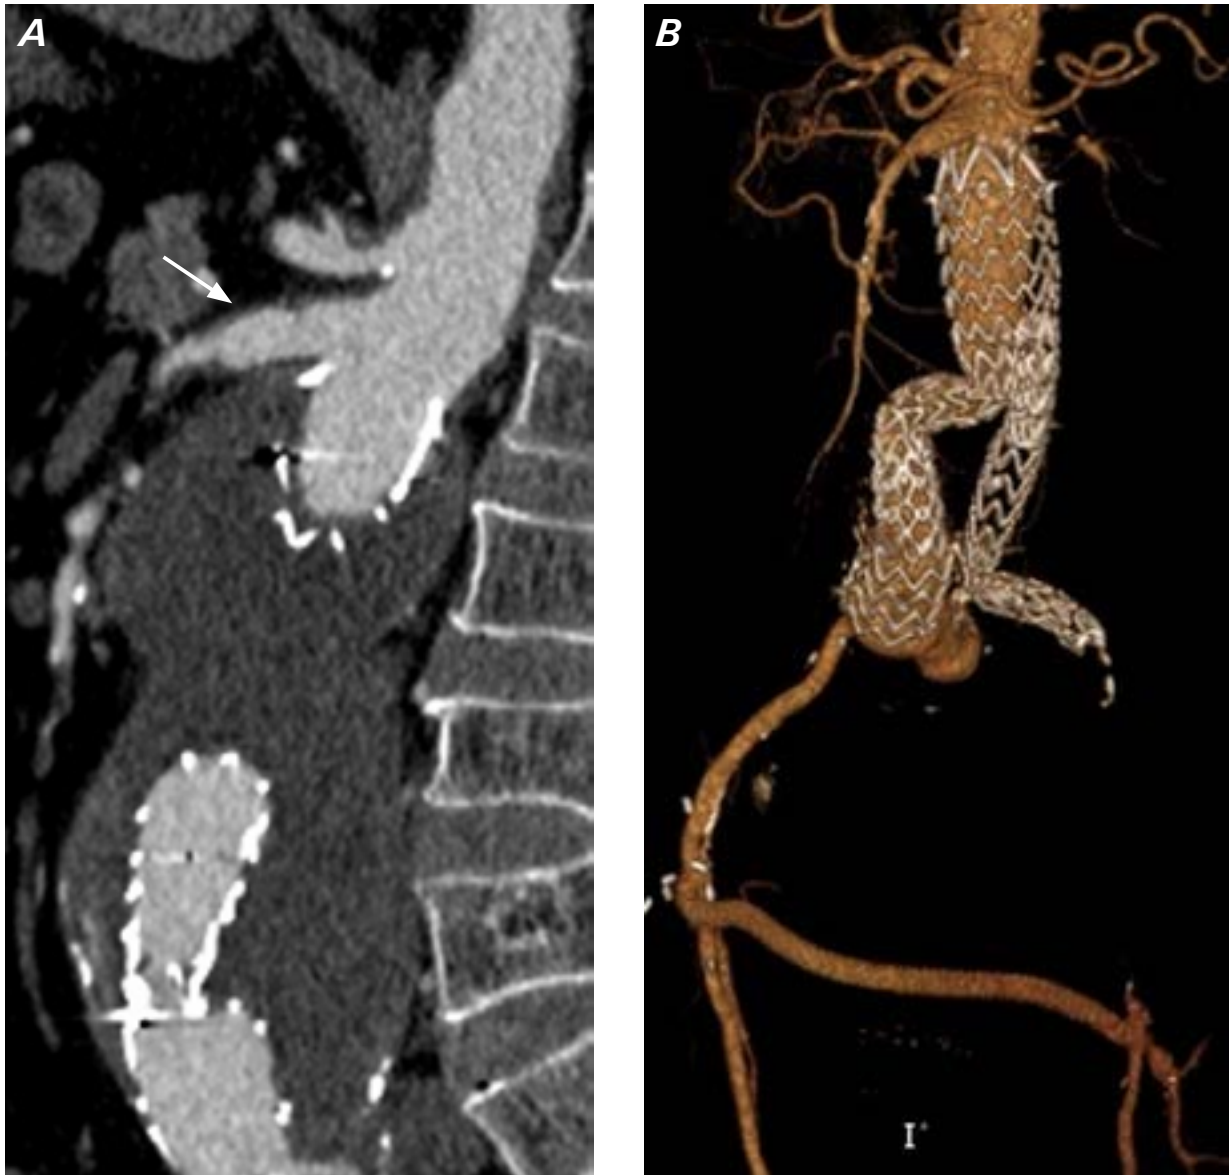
Computed tomographic images of the patient at presentation that shows A) a large abdominal aortic aneurysm sac with barbed wires extending toward the orifice of the superior mesenteric artery (arrow) in a sagittal image. The kinked and occluded left limb of the endograft and a patent cross-femoral graft are seen in B) a 3-dimensional image.
